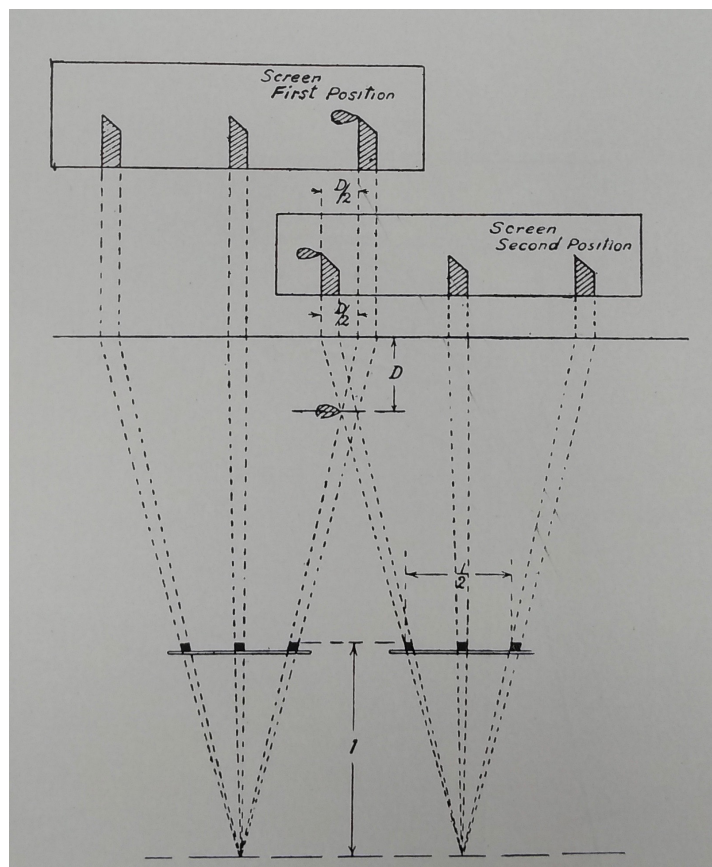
The Hampson calculator for localisation. The 'slide-rule localiser' recommended by the War Office X-ray Committee would have been very similar.
